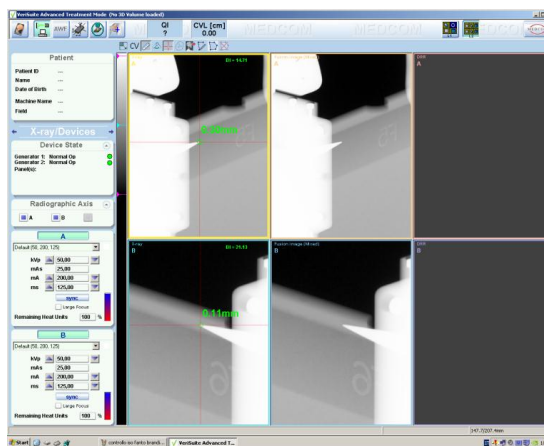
screenshot of Verisuite software. It is possible to note the red cross on the Xray images corresponding to the center of the flat panels. Tool is aligned with <1mm accuracy.
